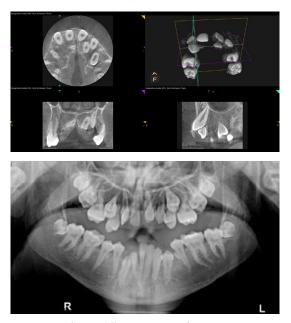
(a,b) Maxillary CBCT and panoramic radiograph showing the impacted dentition in both arches.
